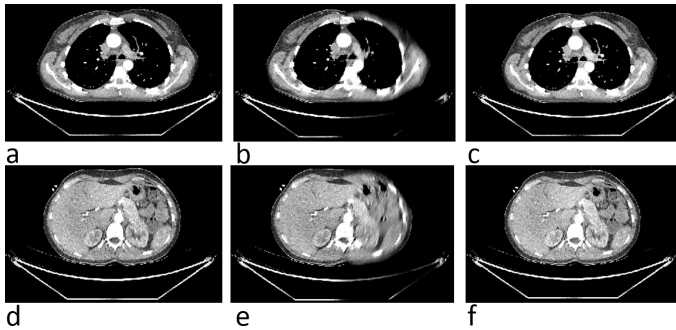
Comparison between reconstructed cardiac CT images in the chest and liver regions. a, and d. Full-scan MBIR. b, and e. Half-scan MBIR. c, and f. SAW-MBIR. Window settings show the [-200 200] HU range. SAW-MBIR shows consistent image quality with full-scan outside the heart where half-scan MBIR is distorted. Panels a-c correspond to a slice between cross sections c and d (closer to d at the edge) in Fig. 1, and panels d-f are from a slice on the opposite side in the reconstructed volume.
